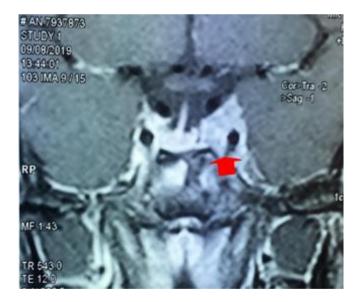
Coronal CT scan of the brain showing a latero-sellar lesion process infiltrating the cavernous sinus
